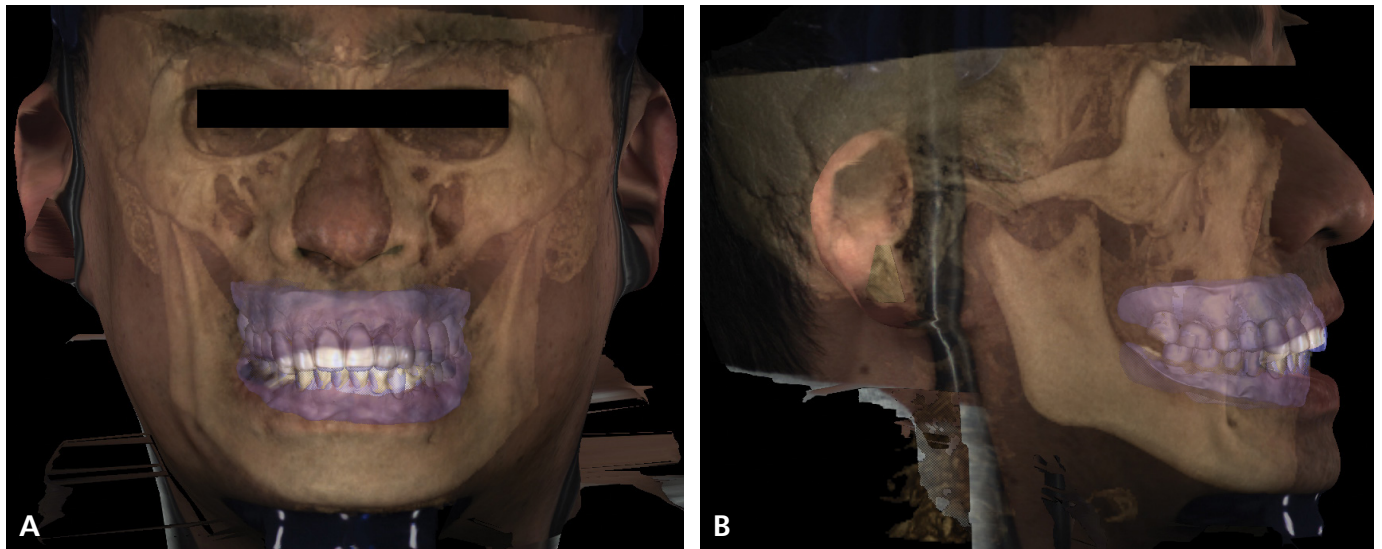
Provisional prosthesis design with facial scan and CBCT along the bony and soft tissue landmarks. (A) Frontal view. (B) Lateral view.
